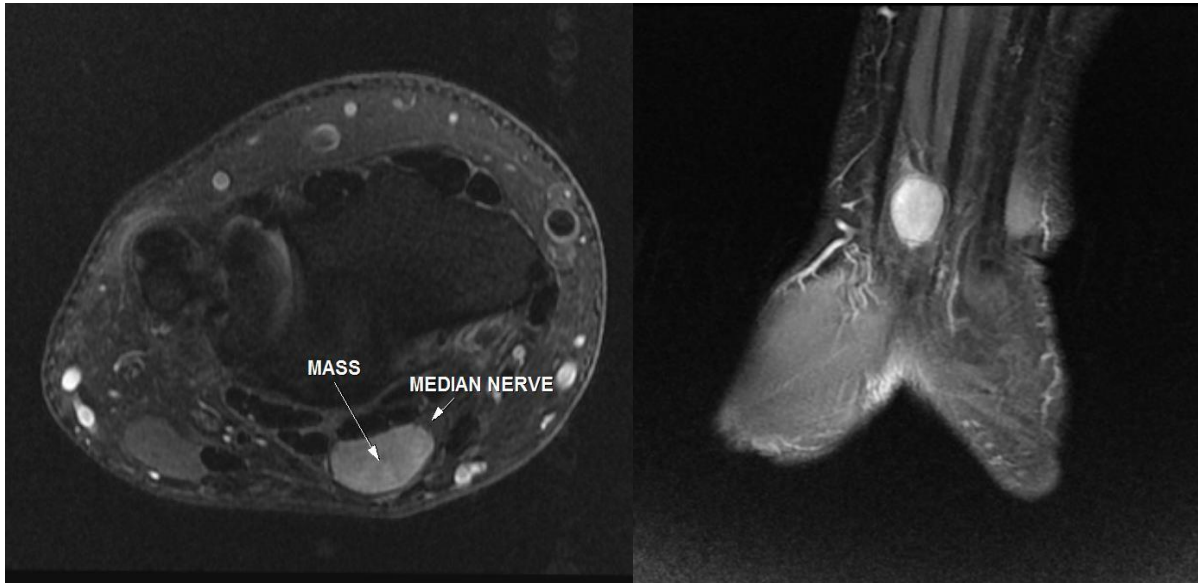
MRI of the Wrist in T2 FATSAT Weighted Sequences on Axial (A) and Coronal Plans (B) Showing an Encapsulated Mass Depending on the Peripheral Parts of the Median Nerve in Homogenous High Signal.
